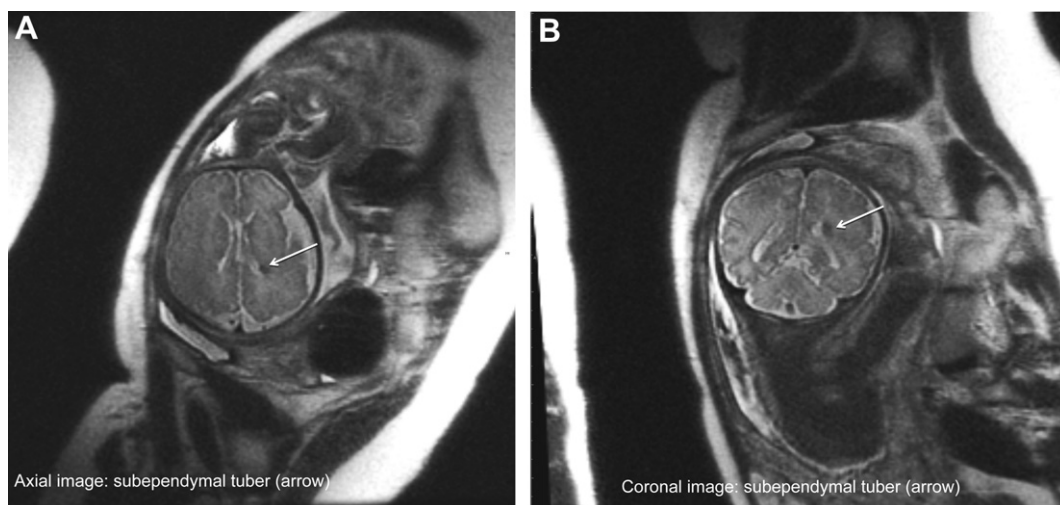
(A and B) Ultrafast magnetic resonance imaging of the brain reveals small subependymal tubers (arrows).
